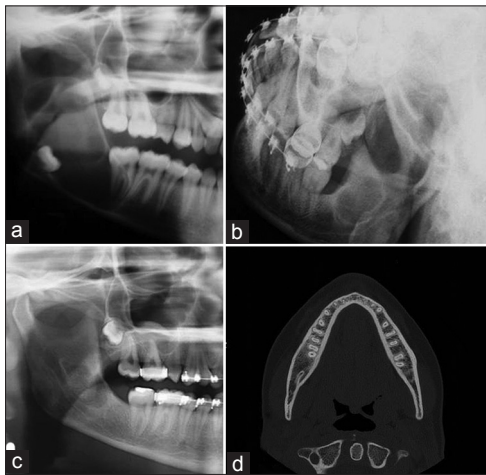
(a) The initial panoramic radiograph showing multilocular radiolucency well-circumscribed associated with impacted teeth, involving ramus and angle of mandible, (b) The oblique of mandible and, (c) panoramic radiograph at 28 months after the surgery revealing radiolucency in posterior region of mandible. (d) The computerized tomography image showing the presence of two parallel hyperdense lines in posterior region of right body of mandible, compatible with bifid mandibular canal
